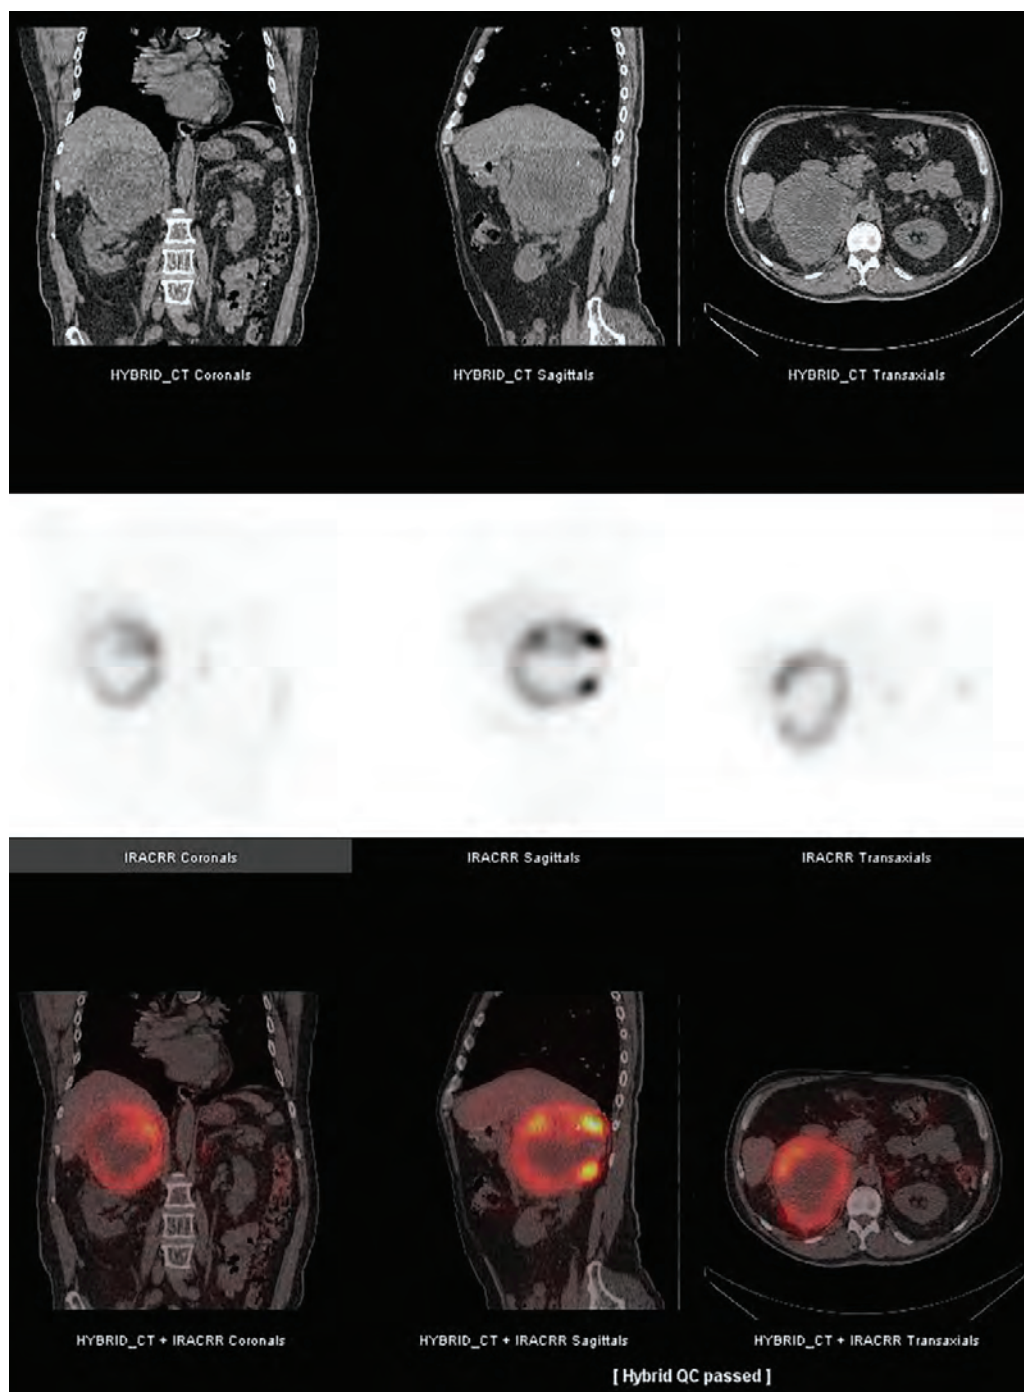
CT images of a patient (top), SPECT images of the same patient (middle) and SPECT-CT images fused with each other (bottom), showing how the hybrid technologies complement each other to provide more information for a nuclear medicine physician to arrive at a diagnosis. (Photograph courtesy of J. Dickson, University College London, United Kingdom.)
